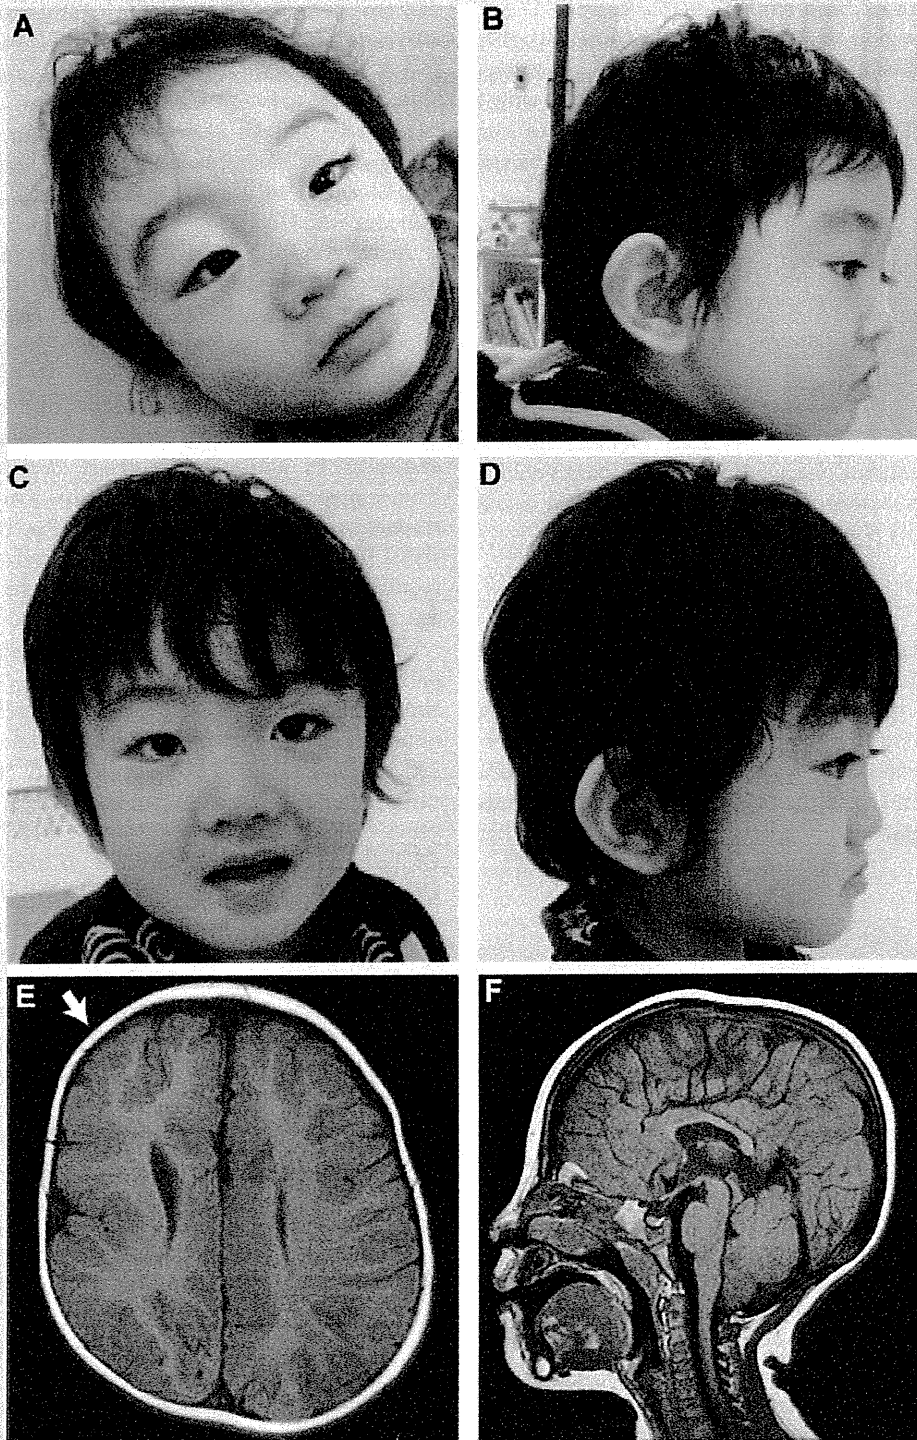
Clinical features of the patient. A–D: Facial appearance of the patient at age 11 months (A), 18 months (B), and 22 months (C,D). He showed dysmorphic facial features, including iris coloboma and low-set ears. E,F: Brain magnetic resonance imaging of the patient at age 18 months. T1-weighted coronal (E) and sagittal (F) sections are shown. Polymicrogyria is seen in the right frontal operculum-perisylvian region [white arrow].
